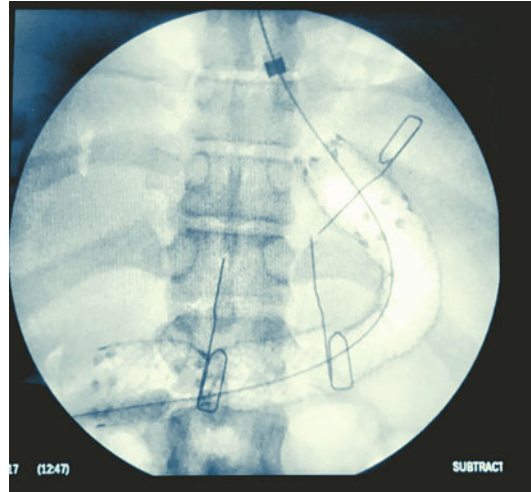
X-ray image of sleeve leak showing fully covered metallic stent, positioned from distal esophagus to duodenum first portion
